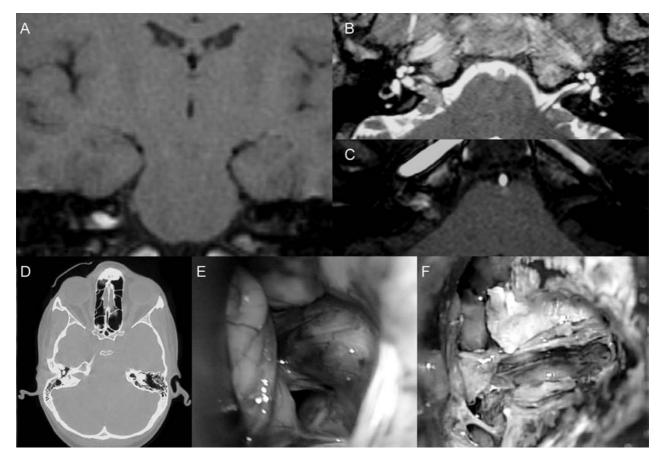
Coronal (A), and axial (B and C) magnetic resonance imaging showing a right intracanalicular mass that extends minimally to the cerebellopontine angle. The mass showed only slight enhancement after gadolinium administration (A and C). Dilatation of the right IAC but no calcification was seen on a CT bone scan (D). Intraoperative image (E) showing the cavernoma protruding from the internal acoustic canal. The lesion appeared as a reddish soft mass composed by multiple sinusoidal vessels originating from the VIII nerve. The anatomical continuity of the VII nerve was preserved (F)
